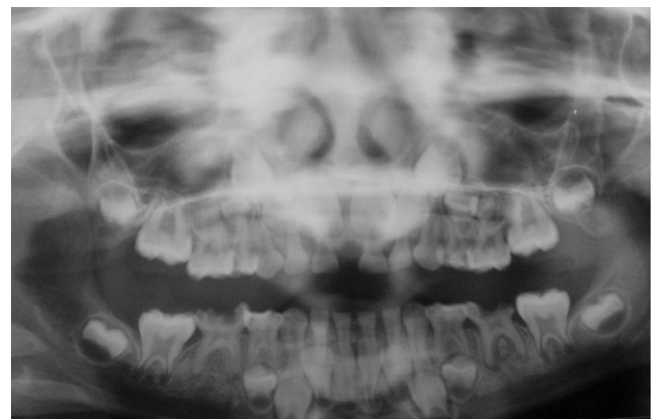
Panoramic radiograph of a 7-year-old patient at diagnosis who was submitted to chemotherapy and 2,100 cGy irradiation. Note agenesi of the lower right second premolar, taurodontism of the first permanent molars and microdontia of the upper and lower left premolars.
